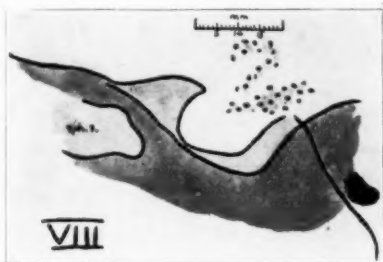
(case 8).—A sketch of the roentgenogram (fig. 26), drawn to scale.
